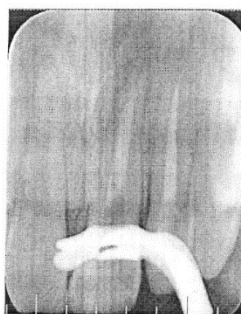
Radiographic view of the MTA apical plug
